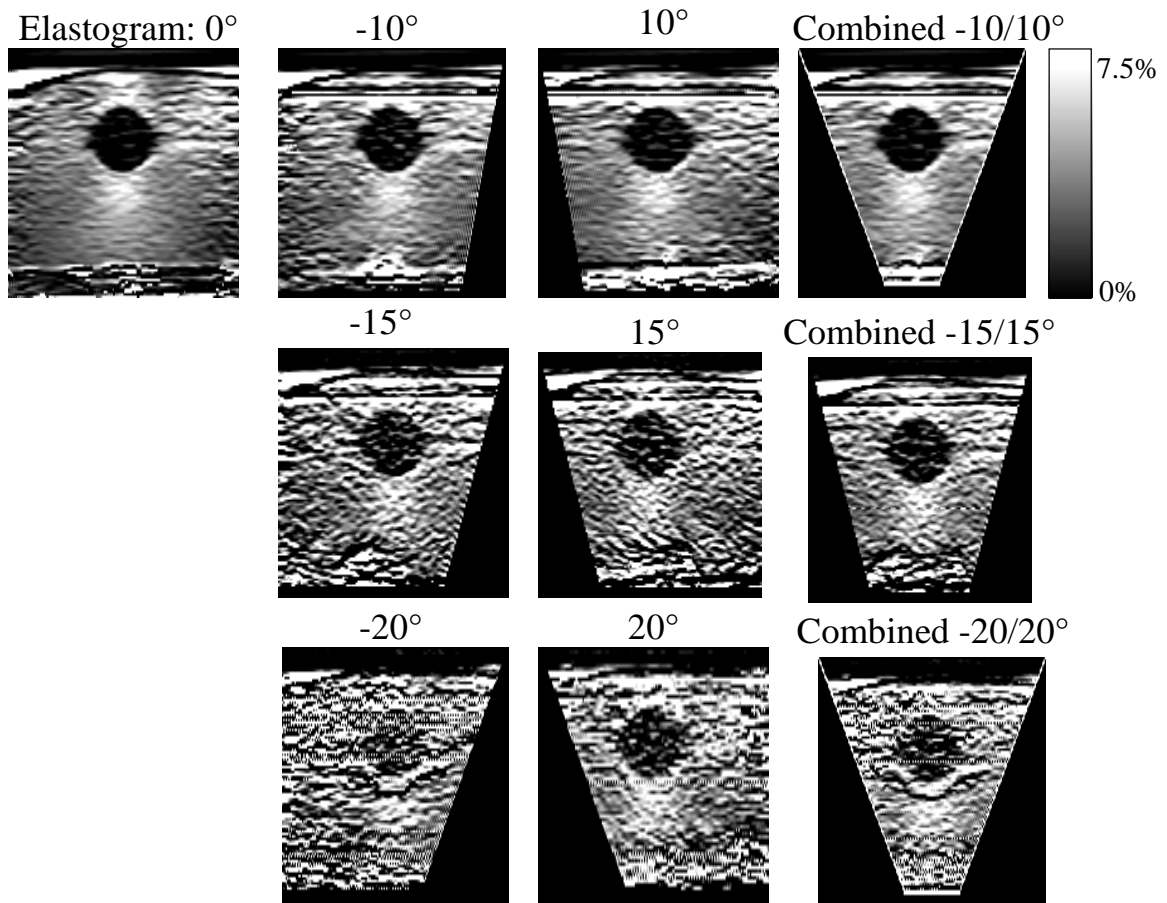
Final elastograms created from ultrasound images created at multiple insonification angles. The poor elastogram image quality is most likely due to losses in ultrasound image quality by imaging through the mammographic paddle.
